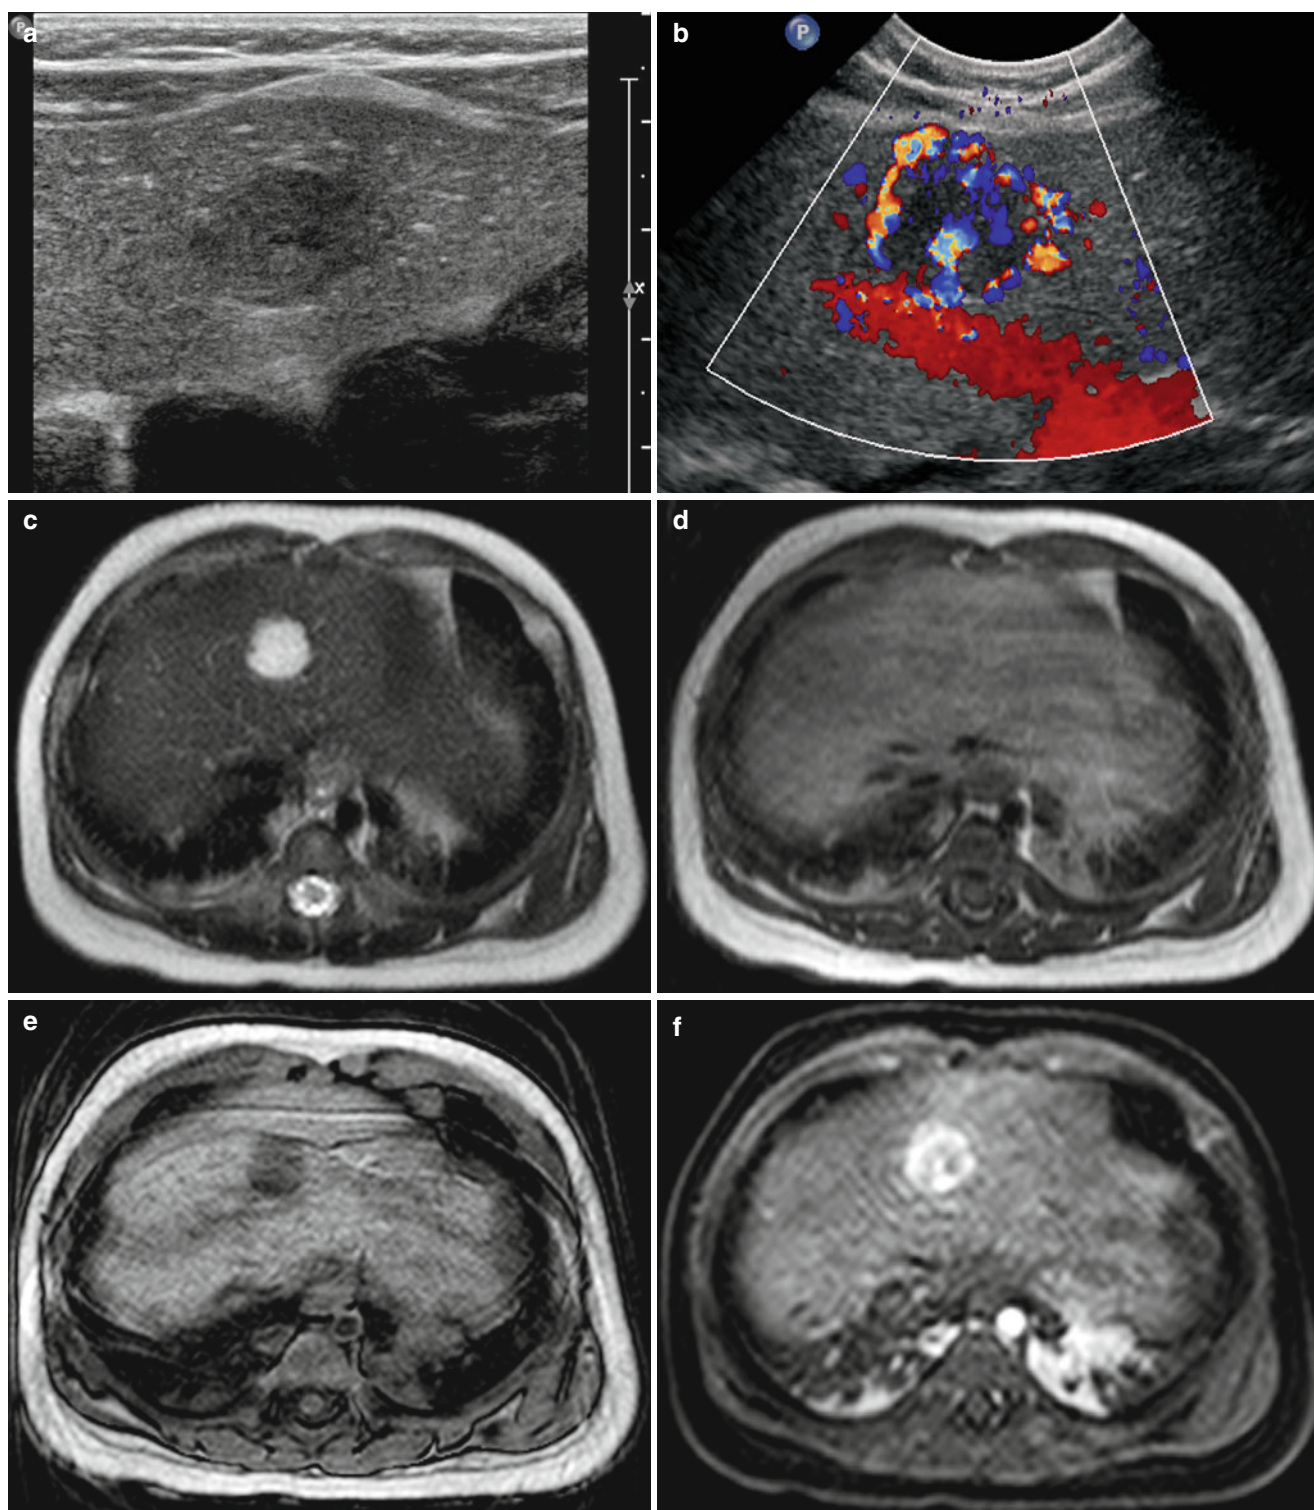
Hepatic hemangioendothelioma in a 2-month-old girl. (a) Abdominal US shows lobulated hypoechoic mass in liver dome. (b) Color Doppler US shows marked increased vascularity in this mass. (c) T2-weighted MR image shows marked high signal intensity of this mass. (d) On T1-weighted MR image, this mass shows iso-signal intensity to surrounding liver parenchyma. (e–g) T1-weighted images with fat suppression show signal drop in this mass on pre-contrast image (e), marked peripheral enhancement on arterial phase image (f), and central progression of the enhancement on delayed image (g). Initial AFP level was 646 IU/mL.
